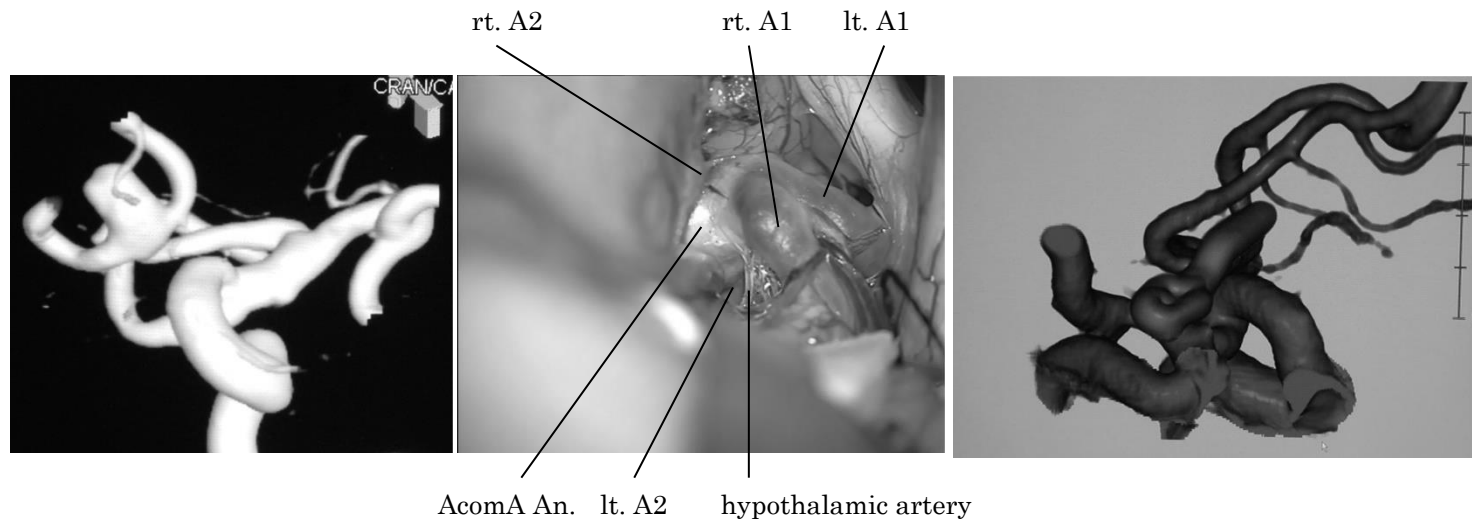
A 62-year-old woman with an AcomA An. CTA showed that an AcomA complex had reversed torsion (A). Rt. PA was performed. Intraoperative findings clearly revealed an AcomA complex, hypothalamic artery, and An.(B). A complete obliteration of the An. and preservation of each branches was confirmed by postoperative CTA (C).
